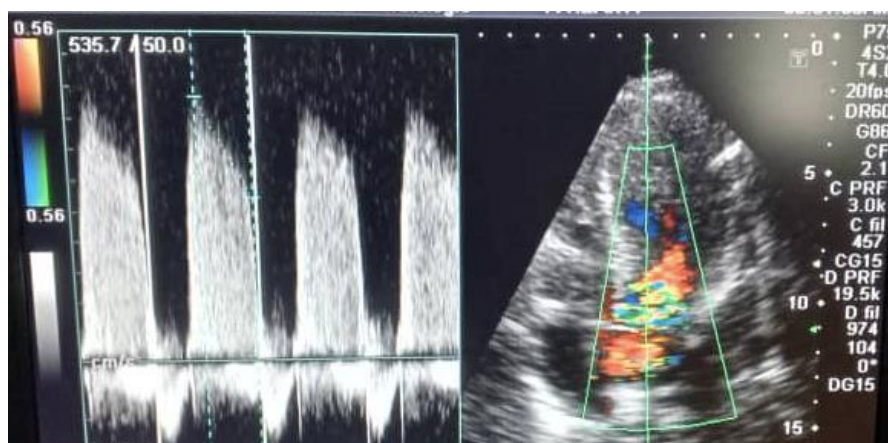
Transthoracic echocardiography, apical 4-chamber view, color and continuous-wave Doppler showing aortic regurgitation (Case 2).
